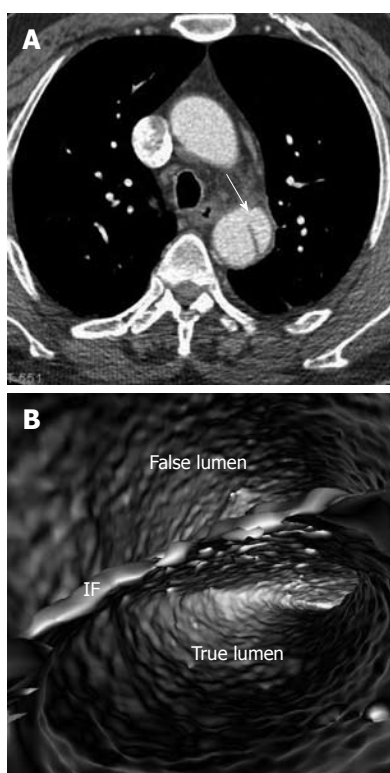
Stanford type B dissection with similar computed tomography attenuation in both true and false lumens (A). Virtual intravascular endoscopy clearly demonstrates the true and false lumens separated by the intimal flap (IF) in a single image (B). Arrow in A indicates the intimal flap.
